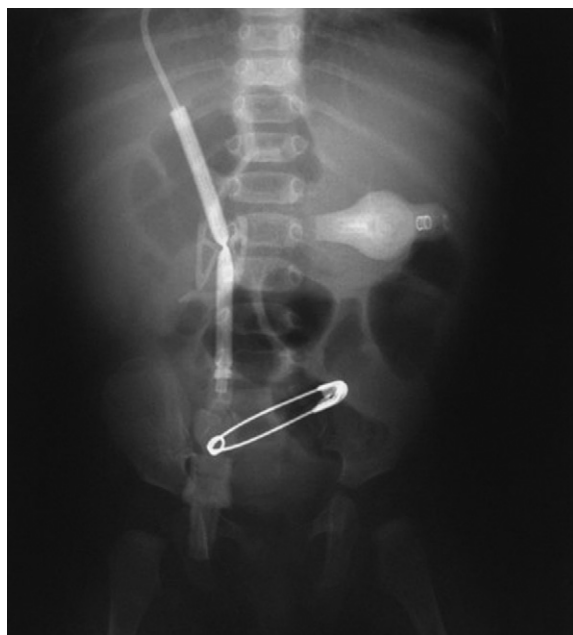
This abdominal radiograph is stereotypical of a young child with short bowel syndrome. There are a few moderately dilated intestinal loops with no clear evidence of mechanical obstruction. A G-button and central line may be noted.
